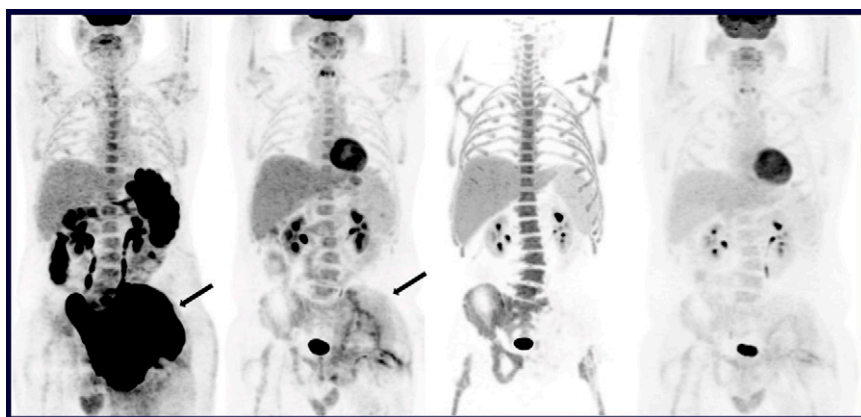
^{18}F -FDG and ^{18}F -FLT PET in diffuse large B-cell lymphoma. Example images in a patient before and after R-CHOP therapy (left to right): ^{18}F -FDG PET at baseline; ^{18}F -FDG PET after 2 cycles of therapy indicating a partial response; negative ^{18}F -FLT after 2 cycles of therapy; and end-of-treatment ^{18}F -FDG PET indicating complete response.
